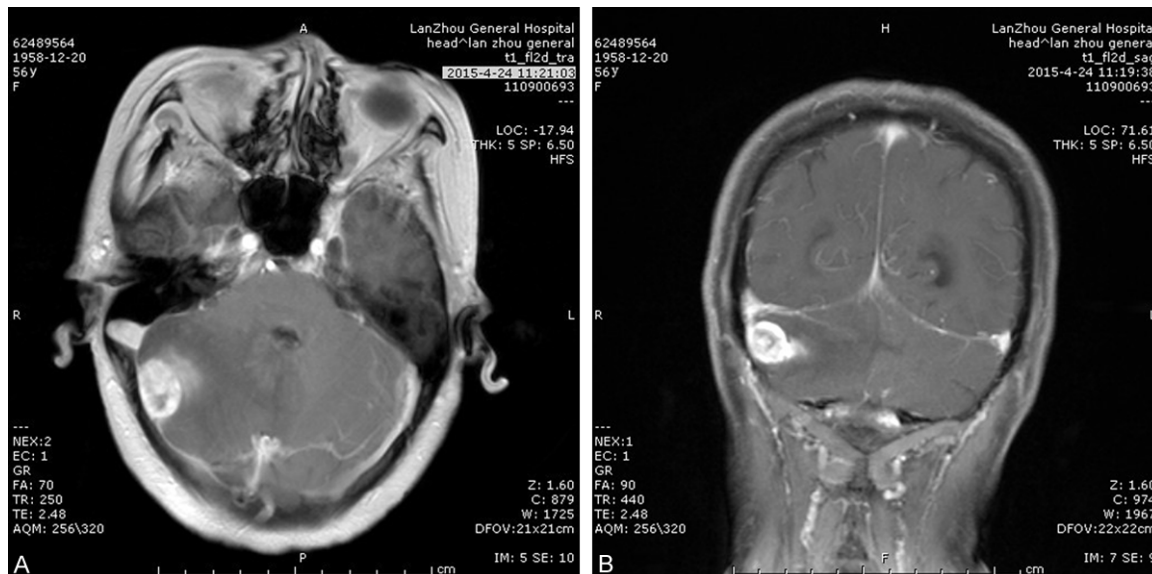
A cranial magnetic resonance imaging (MRI) revealed showed a nodular with equal T1-weighted image and shorter T2-weighted image abnormal signal intensity which was about 1.4 × 2.1 cm and clear boundary near meninges in the right cerebellar hemisphere. Fluid attenuated inversion recovery (FLAIR) showed equal signals and diffusion weighted imaging (DWI) showed a high and low heterogeneous signals. The edge of nodular surrounded by edema which was a large patchy long T1-weighted image Signals and longer T2-weighted image signal intensity in the sagittal (A) and coronal (B) plane.
